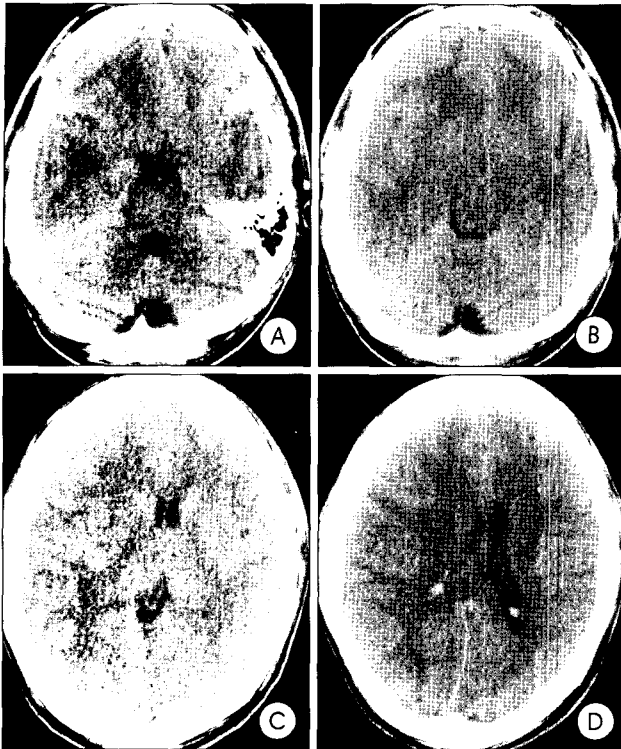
A-D : Brain computed tomography scans of patient 2 taken before neurological deterioration, showing a thin subdural hematoma over the right cerebral hemisphere and along the tentorium with midline shift.
